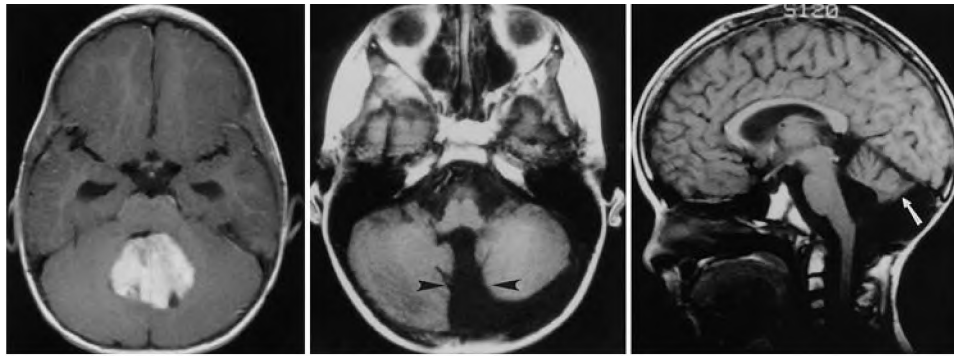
Case 5. A 3-year-old boy with a split inferior vermis who developed postoperative mutism. *Left:* Preoperative T<sub>1</sub>-weighted magnetic resonance (MR) image with gadolinium enhancement showing a diffusely enhancing midline lesion blocking the fourth ventricle. *Center:* Axial T<sub>1</sub>-weighted MR image performed postoperatively revealing the split in the inferior vermis (*arrows*). *Right:* Sagittal T<sub>1</sub>-weighted MR image showing the rostrocaudal extent of the split of midline structures. The split extends through the pyramis to the prepyramidal fissure (*arrow*).
